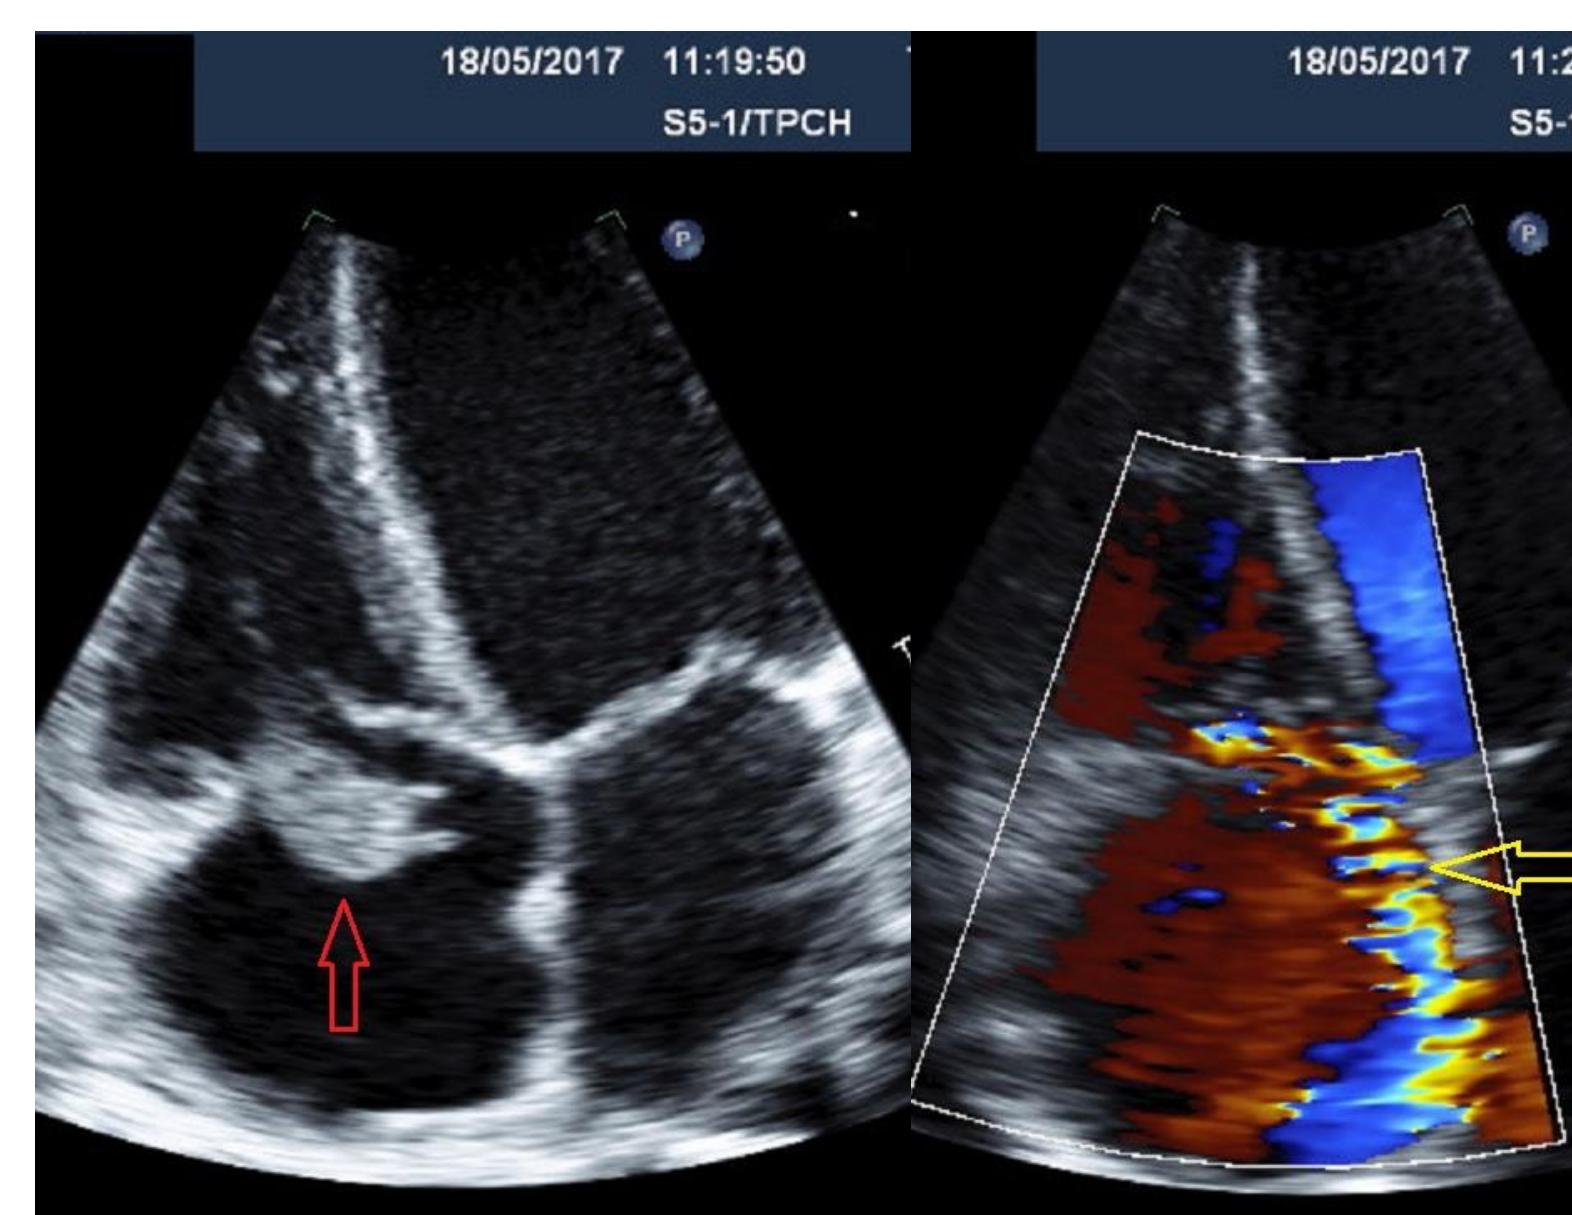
Transthoracic echocardiogram (tricuspid valve) showing a large independently mobile mass (red arrow) attached to the anterior leaflet of the tricuspid valve (1.5 x 2.5 cm). There is a large coaptation defect with associated eccentric, medially-directed severe regurgitation (yellow arrow).
